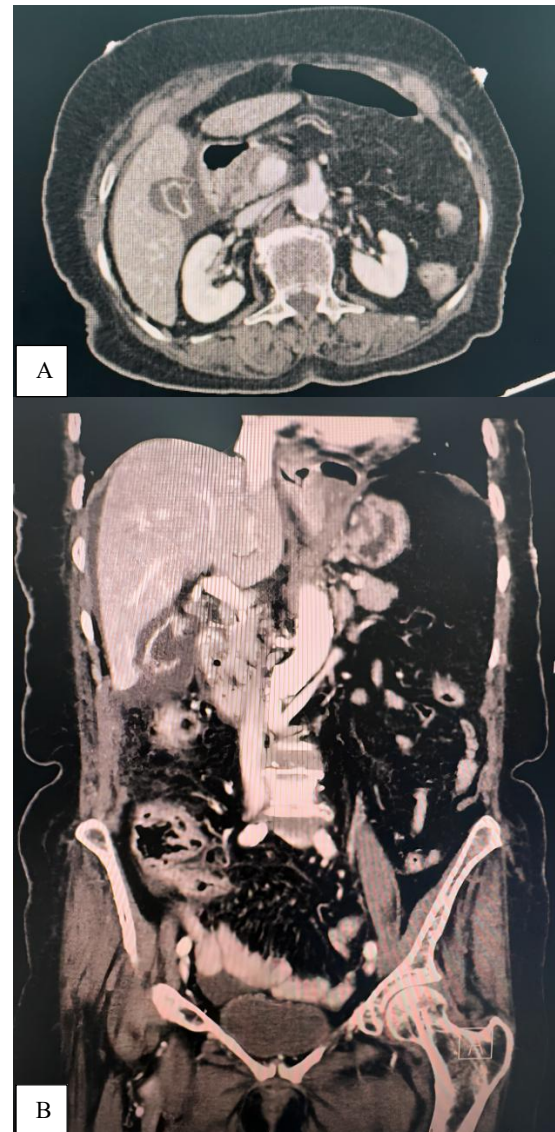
(A) CT scan showed a perforated GB and (B) a CT scan showed perforated GB; coronal view.
